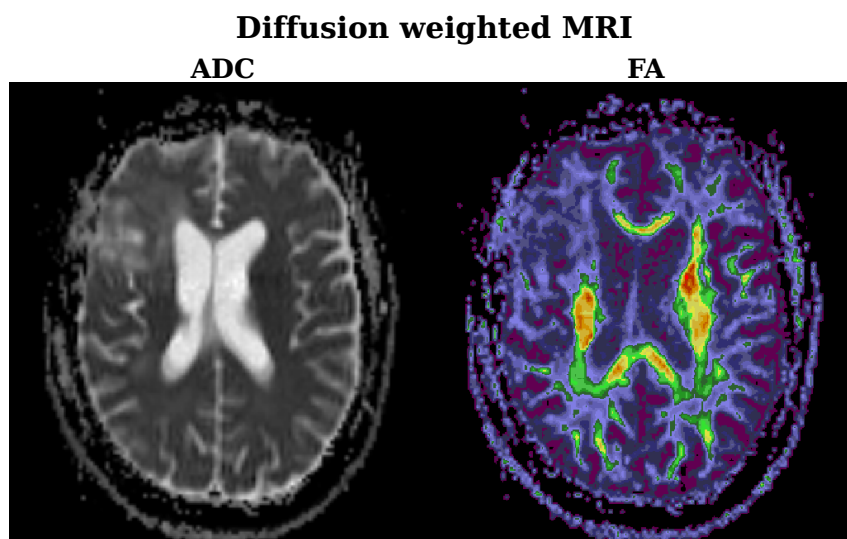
Parameter maps of the ADC and the FA from diffusion weighted MRI in a recurrent glioma patient. In liquids, such as the CSF in the ventricle, diffusion is more free compared to tissue, where the cells restrict diffusion. This leads to an enhanced ADC , indicated by a brighter image signal. In the FA , nerve fiber structures are indicated since they induce more directed diffusion compared to regions of isotropic diffusion such as the CSF.
